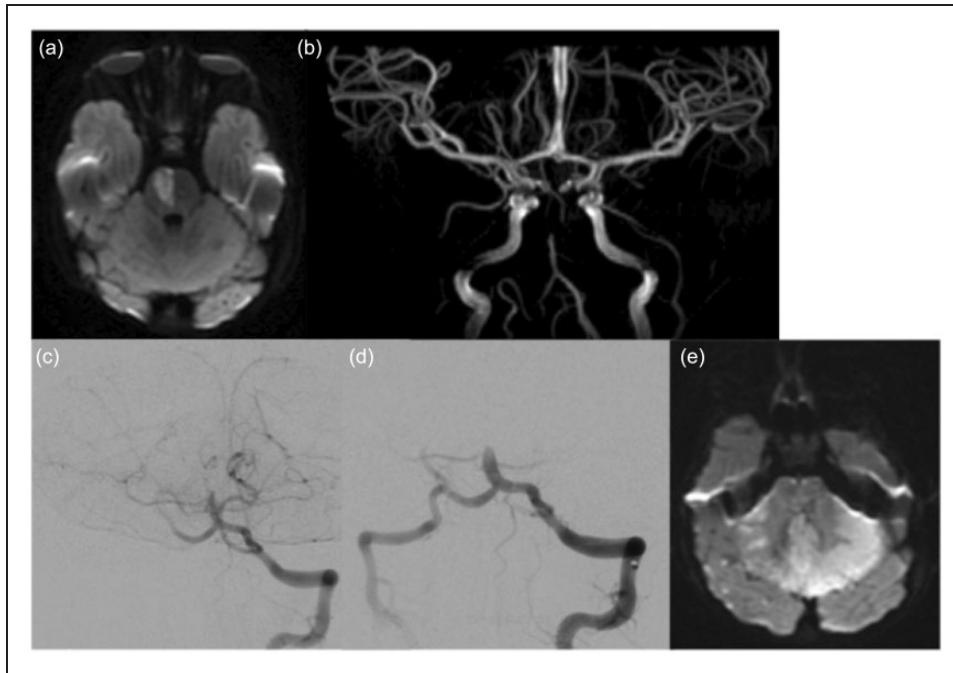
A 2-year-old child presented with acute hemiparesis and somnolence. MRI was performed at 20 hours after onset, showing acute paramedian pons ischemia on the DWI (a), and occlusion of the mid-basilar artery on the MR angiogram (b). Findings were thought basilar artery was confirmed (c), and several attempts to recanalize it failed (d). Diffusion weighted imaging at 24 h post treatment showed extensive ischemia of the brainstem and cerebellum (e), and the patient did not survive.
